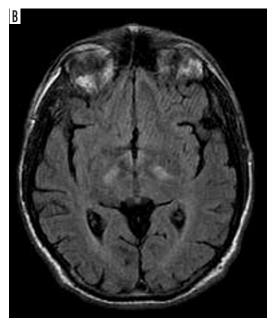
Hyperintense areas in dentate nuclei of cerebellum bilaterally on axial T2-weighted magnetic resonance imaging (A) and in posterior limbs of both internal capsules on FLAIR sequences (B)
